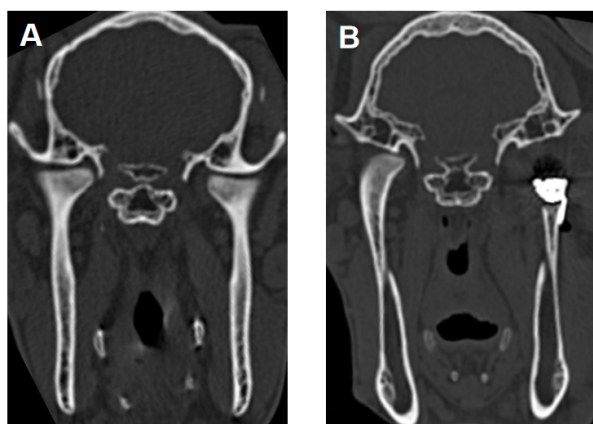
Coronal computed tomography (CT) images. (A) Preoperative CT scan. (B) Postoperative CT scan at six-month follow-up.
